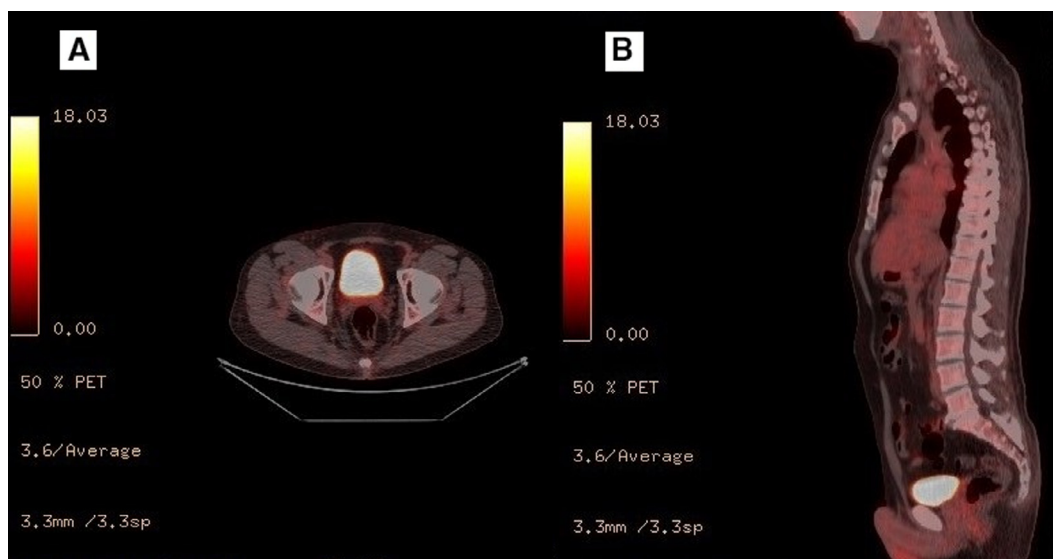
PET/CT evaluation with ^{18}F -fluorodeoxyglucose, executed a months before the access in emergency department, showing in axial (A) and sagittal planes (B) no FDG uptake resulting as a remission of original lymphoma. PET/CT, positron emission tomography - computed tomography; FDG, ^{18}F -fluorodeoxyglucose.
